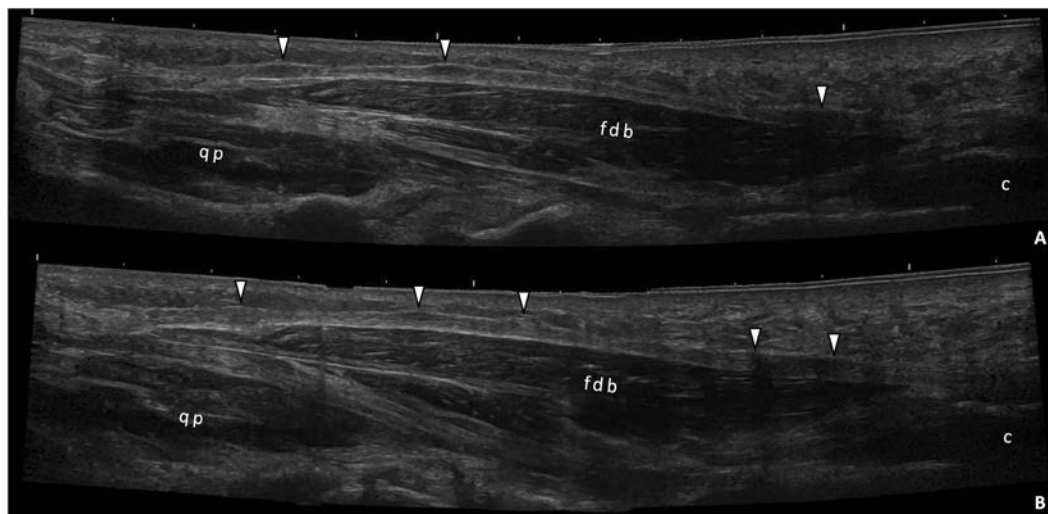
Panoramic ultrasonographic images of the plantar fasciae of the left (A) and right (B) feet showing diffuse hypoechoic nodules (arrowheads) consistent with bilateral plantar fibromatosis. c: Calcaneus, fdb: Flexor digitorum brevis muscle, qp: Quadratus plantae muscle.
